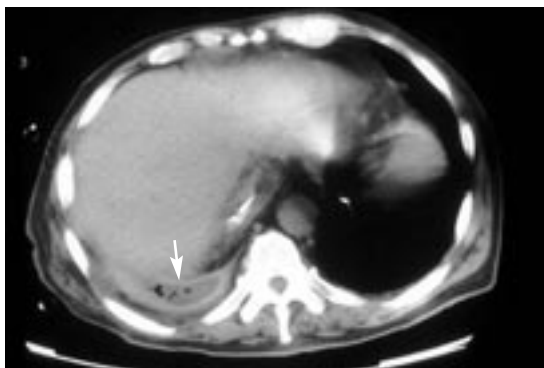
Chest computed tomographic scan with a “split pleural sign” (arrow), seen in empyema. This patient needed drainage with tube thoracostomy.
